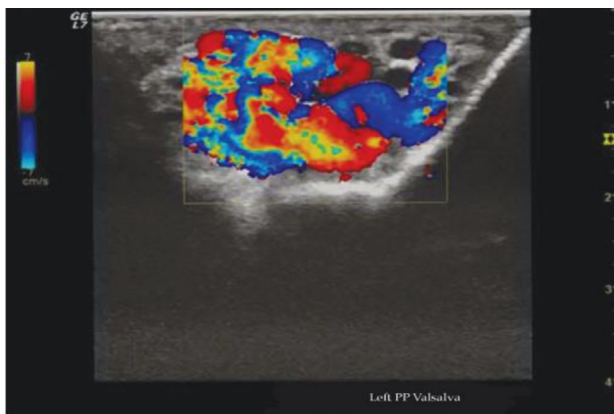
Color Doppler ultrasound of the scrotum showing dilated left pampiniform venous plexus with augmentation after valsalva maneuver.
